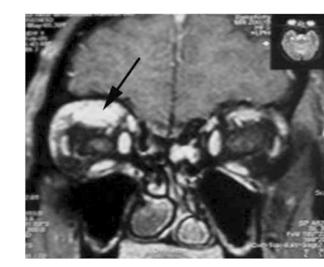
A MRI coronal scan of the orbit showed the mass to be distinct from the right superior rectus and appear to involve only the right levator superioris.
